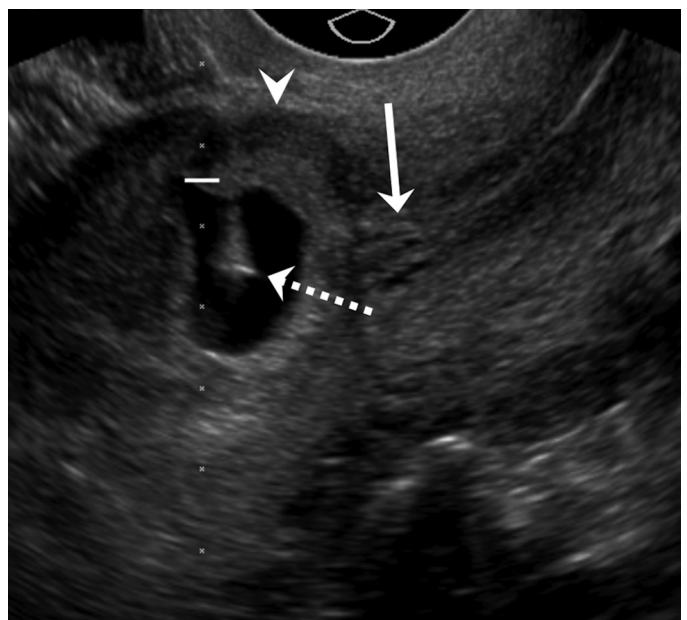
Transvaginal, ultrasound-guided injection of potassium chloride into an ectopic pregnancy at a cesarean delivery scar. The needle tip (*dashed arrow*) is centered within the gestational sac. Note the typical features of cesarean delivery scar ectopic pregnancy, including eccentric position of a lower uterine segment gestational sac with a thin overlying myometrial layer (*arrowhead*), and closed internal cervical os (*arrow*).
